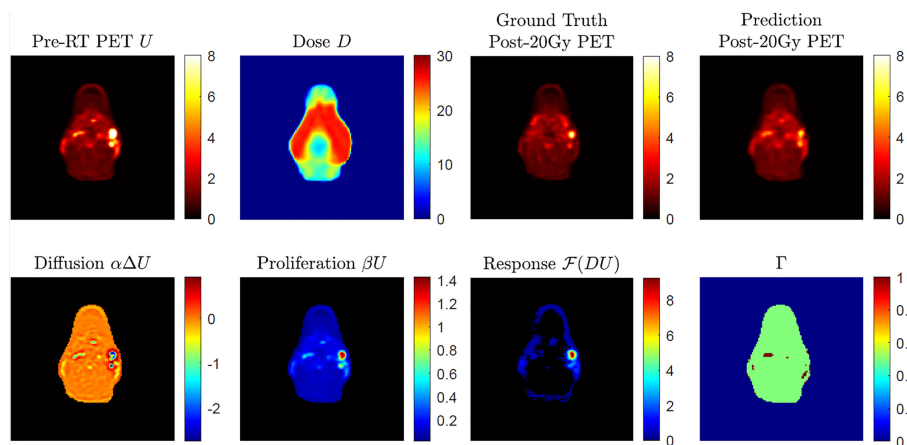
shows an example case of post-20-Gy  $^{18}\text{F}$ FDG-PET image outcome prediction. As seen in the pre-radiation  $^{18}\text{F}$ FDG-PET image, SUV hotspots with clear edges were found on the patient's right side. After 20-Gy delivery shown by the bilateral
